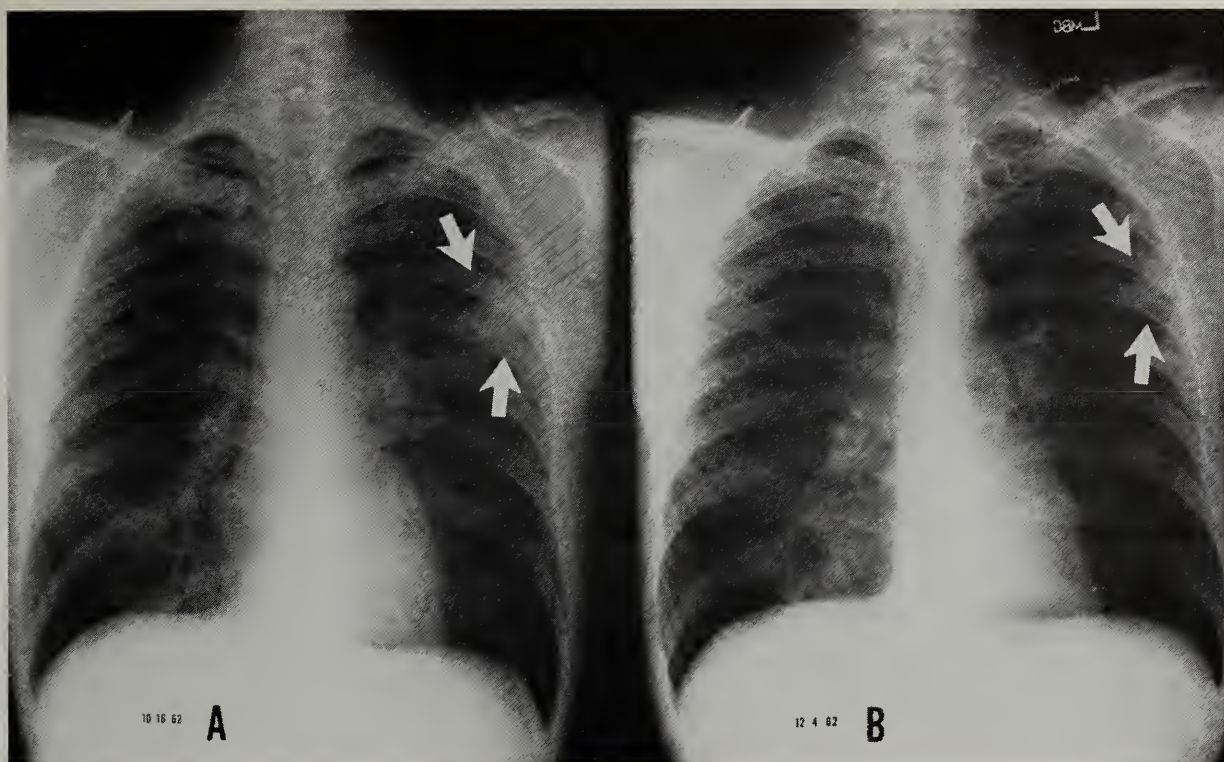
The patient is a 31-year-old white man from San Joaquin Valley with multiple previous episodes of “pneumonia,” hemoptysis and chest pain. Previous chest x-ray films and bronchograms, most recently of August 1962, were negative. Chest x-ray film (A) in October 1962 showed appearance of left hilar adenopathy and a peripheral infiltrate in the left upper lobe. PPD and coccidioidin skin tests were positive. Complement fixation for coccidioidomycosis was positive at 1:2 dilutions. Follow-up x-ray film (B) almost two months later shows interval minimal decrease in the left hilar adenopathy and pronounced decrease in the left upper lobe infiltrate. (Note: Infiltrate at right base 12/4/62 was due to transient aspiration pneumonia following scalene node biopsy.) On 12/20/62, thoracotomy confirmed active coccidioidomycosis in the left upper lobe with subsequent positive cultures.
